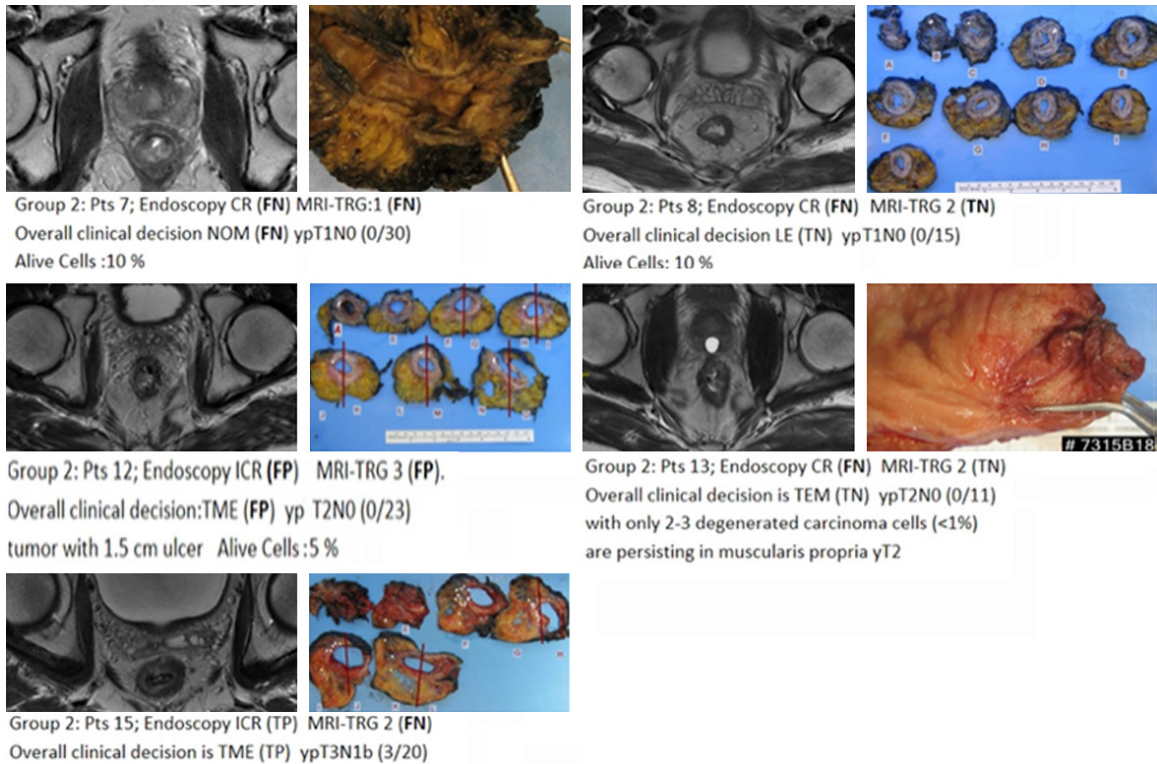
Pathologic data of problematic cases (FN, FP, TP, TN) (Pt 7, 8, 12, 13, 15) as a result of endoscopy, MR or MDT meeting evaluation. In Pt 7, after evaluation of MRI and endoscopy no tumors were not detected and decision was NOM, but the pathology was 10% live cell and YPT1N0 (30/0). When we evaluated Pt 8 endoscopy was normal (white scar) but MRI-TRG score was grade II so the final decision was TEM instead of NOM. Pathology was ypT1N0 so even though endoscopy skipped final decision was right. In Pt 12, TME decision was made in MDT because of endoscopy ICR decision (1.5 cm ulcerous tumor) and MR-TRG SCORE III (incomplete). However, TEM could be performed with because of the pathology, ypT2N0, 1.5 cm ulcer and 5% viable cell. In Pt 13, despite the CR on endoscopy, MR-TRG SCORE was III (incomplete) and MDT decision was TEM; pathologically end-stage YPT2N0 with a viable cell ratio of less than 1% and localized to the muscularispropria. In this case endoscopy was wrong. On Pt 15, the endoscopic response was ICR and the MRI-TRG score was 3 but N+ for the 8 mm lymph node. The MDT decision was TME and the pathology result was ypT3N1b. In this case, 8 mm lymph nodes were negative but other three lymph node which were reported as positive the largest 0.3 mm in diameter and MRI could not evaluate them. On Pt 15, the endoscopic response was ICR and the MRI-TRG score was 3, lymph node recorded as N+ according to the 8 mm diameter. The MDT decision was TME because of suspected lymph node. The pathology result (ypT3N1b) seemed comेतible with MDT decision. But, It was a good decision that was made for the wrong reason, because the radiologically suspected lymph node was negative and there was three pathologic lymph node with the largest 0.3 mm in diameter that MRI could not point them.
